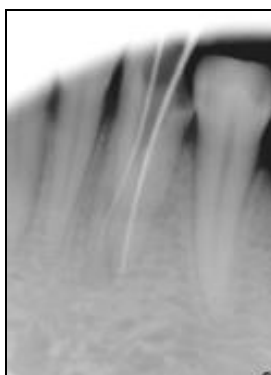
Working length radiograph showing two separate roots and canals
